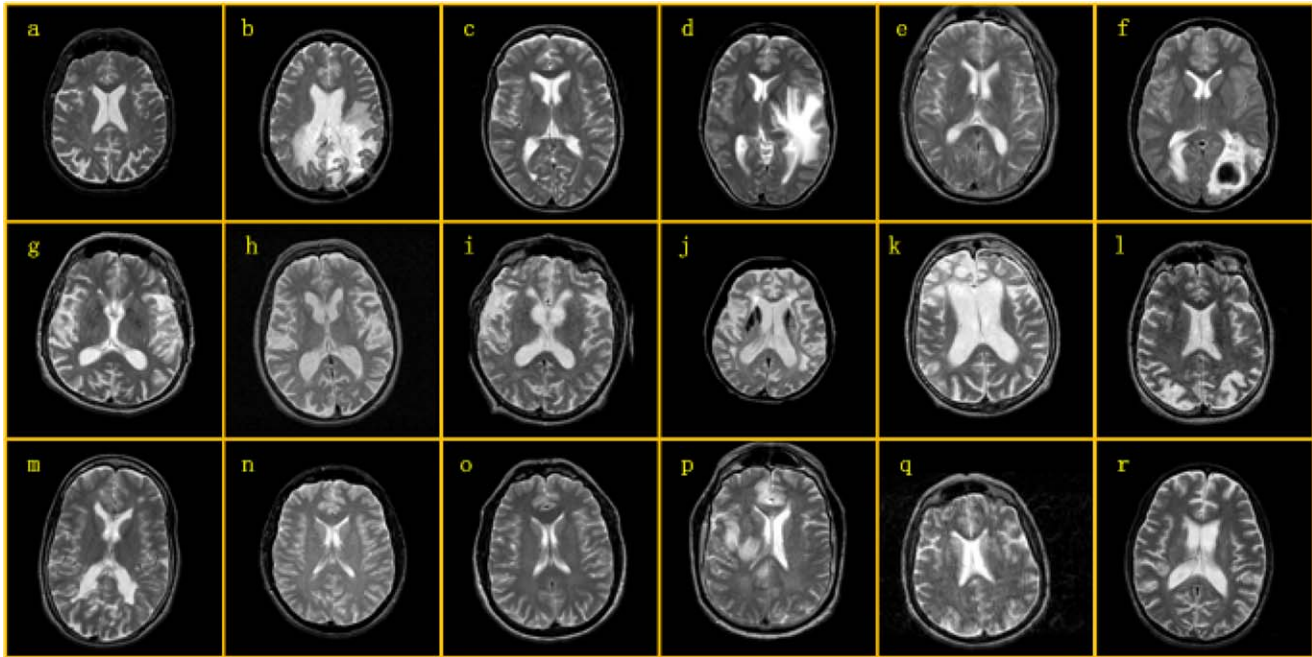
Brain MR images: (a) A healthy brain; (b) Glioma; (c) Metastatic adenocarcinoma; (d) Metastatic bronchogenic carcinoma; (e) Meningioma; (f) Sarcoma; (g) Alzheimer's disease; (h) Huntington's disease; (i) Motor neuron disease; (j) Cerebral calcinosis; (k) Pick's disease; (l) Alzheimer's disease plus visual agnosia; (m) Multiple sclerosis; (n) AIDS dementia; (o) Lyme encephalopathy; (p) Herpes encephalitis; (q) Creutzfeldt-Jakob disease; and (r) Cerebral toxoplasmosis. [Color figure can be viewed in the online issue, which is available at wileyonlinelibrary.com.]
